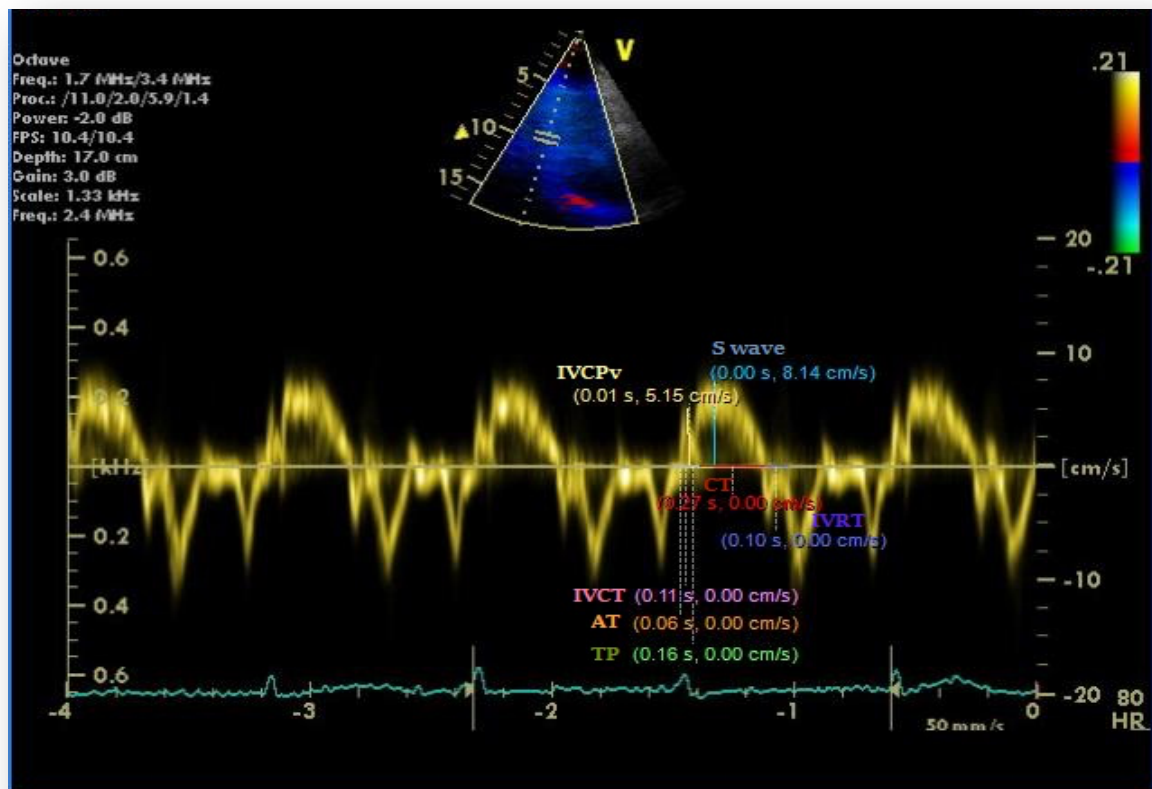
1B. A case of occlusion-RCA before (1A) and after Percutaneous coronary intervention (1B) tissue Doppler imaging (TDI): shows changes in TDI parameters values before and after PCI in basal inferior wall.
